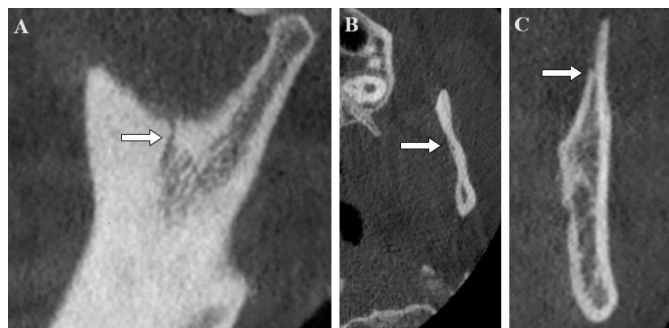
Cone beam computed tomography scan images (A) sagittal section image of sigmoid canal (B) horizontal section image of sigmoid canal (C) coronal section image of sigmoid canal
